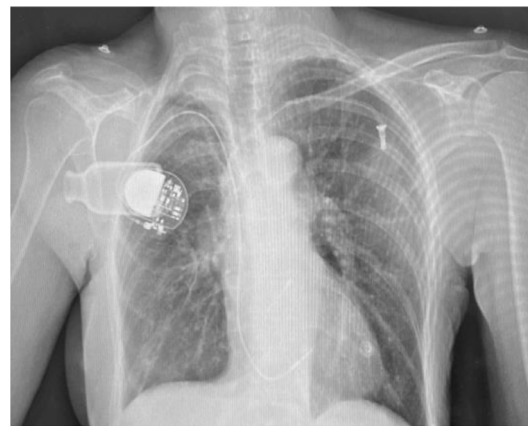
Postero-anterior chest X-ray showing the absence of the right clavicle alongside the presence of a port-a-catheter on the left side. It also rules out the presence of pneumothorax after transvenous pacing.
